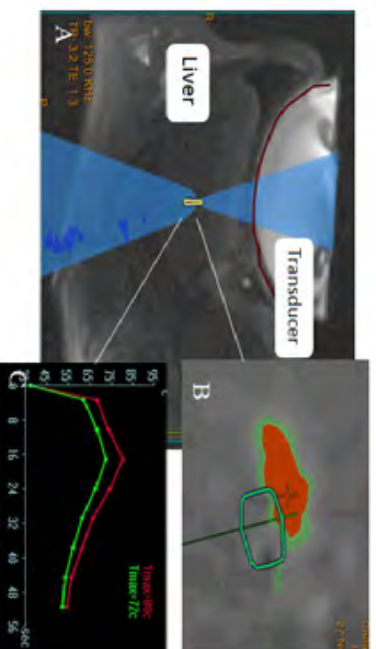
Snapshots of MRgFUS treatment: (A) MR image of the FUS beam path focusing on the liver, (B) post-sonication PRF map showing heated area, (C) post-treatment temperature graph.
